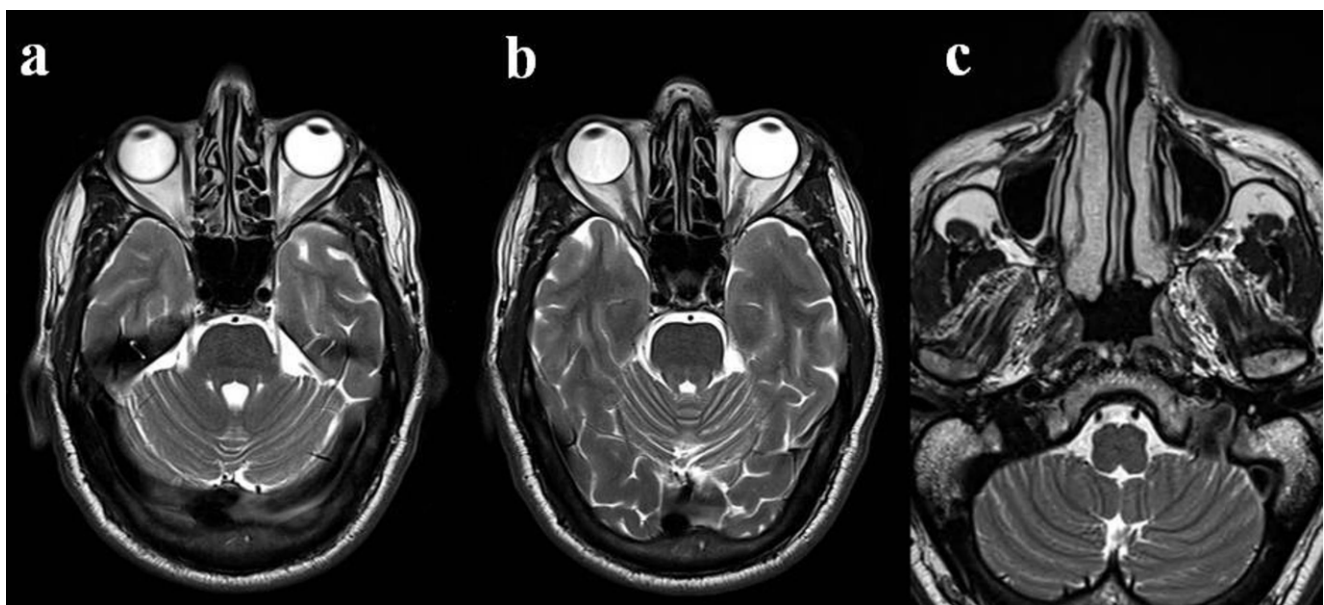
MRI brain showing normal brain parenchyma with normal grey white matter differentiation. no acute infarct, bleed, mass lesion or extra axial collection.
